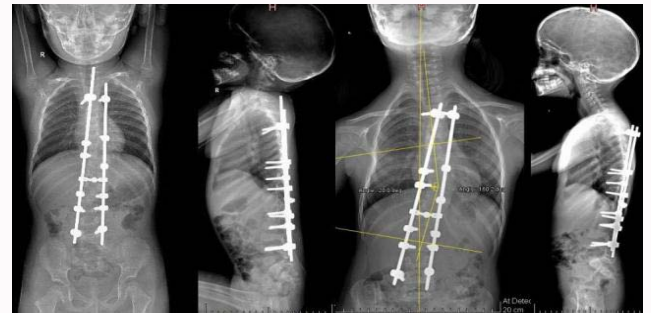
X-rays performed immediately postoperative and 2.6 years after the surgical procedure. The hemi-vertebral spongious enucleation of the supernumerary T11, L2 hemivertebrae, and the growth-guiding device allowing the spinal axis correction. The last follow-up certifies the spinal growth and a 20 degrees Cobb remaining deviation.
